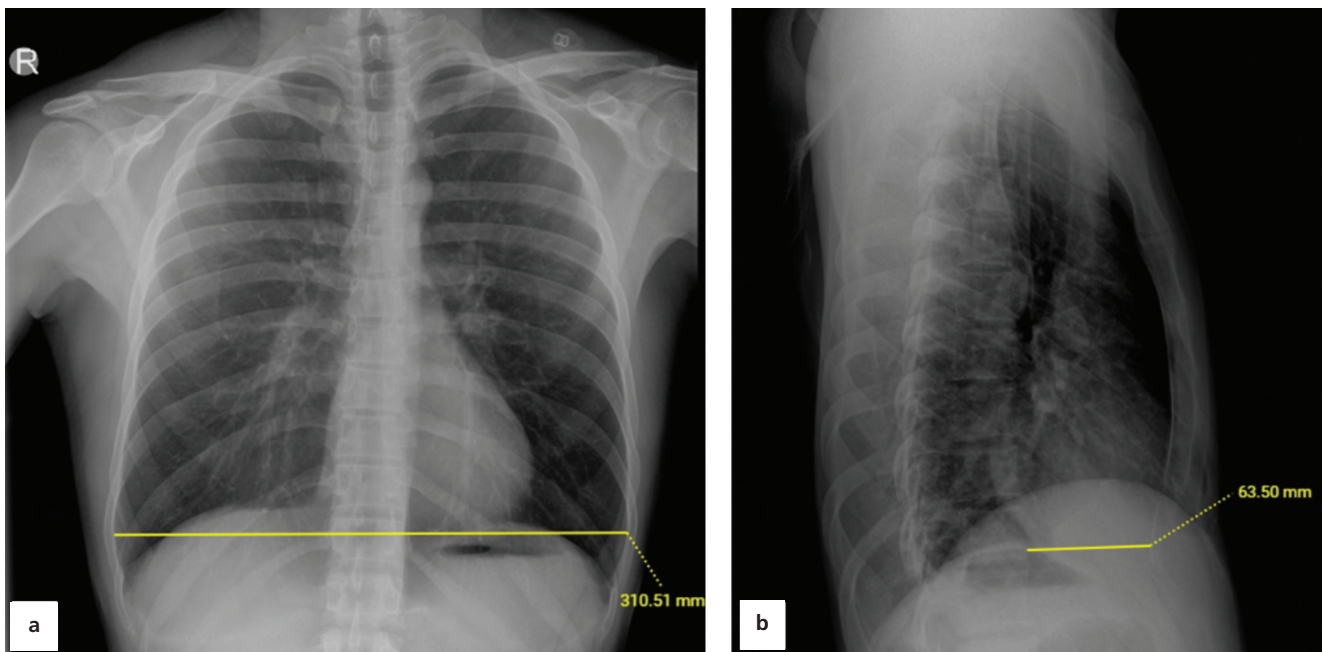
Posteroanterior (a) and lateral (b) two-view chest radiography of a 25-year-old male with pectus excavatum. Haller index was calculated as 4.89.
